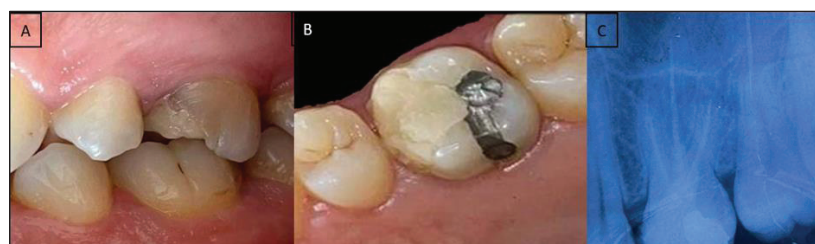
Initial situation (A – buccal aspect, B – occlusal aspect, C – periapical radiograph).
